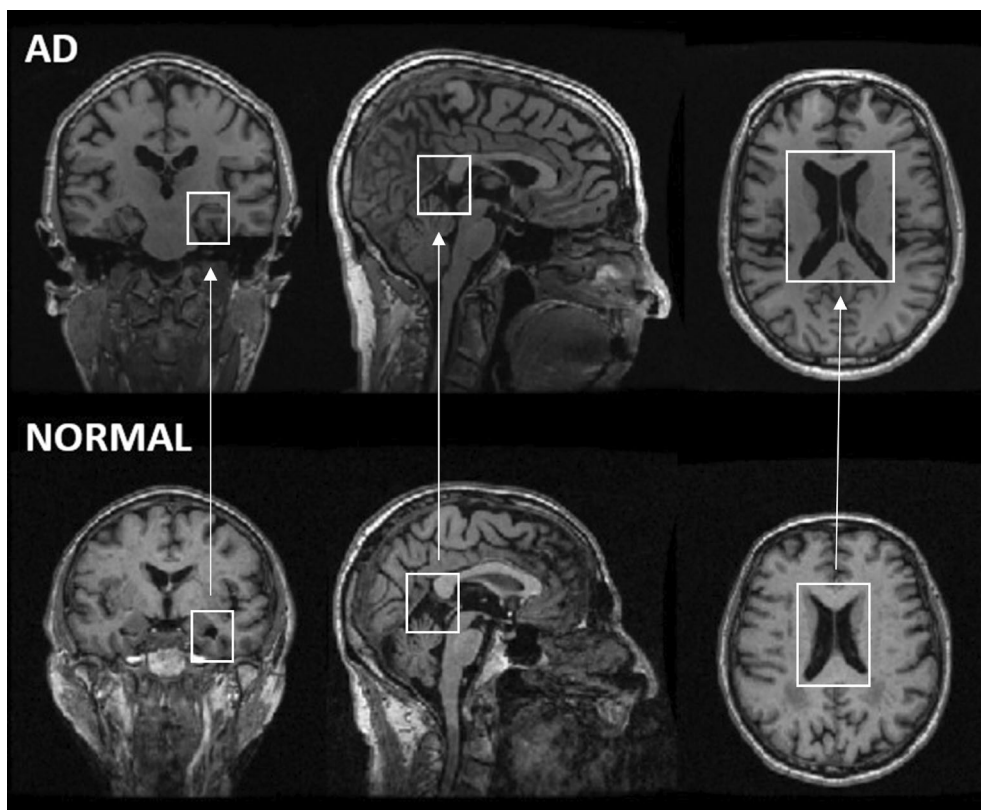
Examples of MRI images of the brain of an Alzheimer's patient and a healthy person taken from the Alzheimer's disease neuroimaging initiative (ADNI) database (ADNI (n.d.)). These images have morphological differences, which are identified in each of the images, between normal controls and Alzheimer's patients that can be perceived by magnetic resonance imaging.
